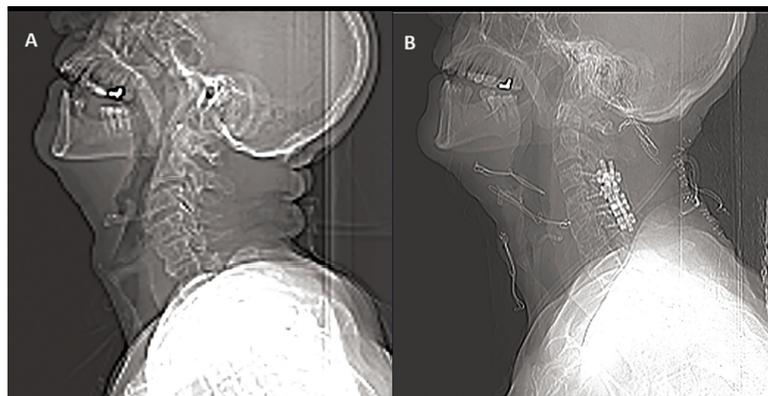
Preoperative (A) and postoperative (B) CT lateral scout views.
